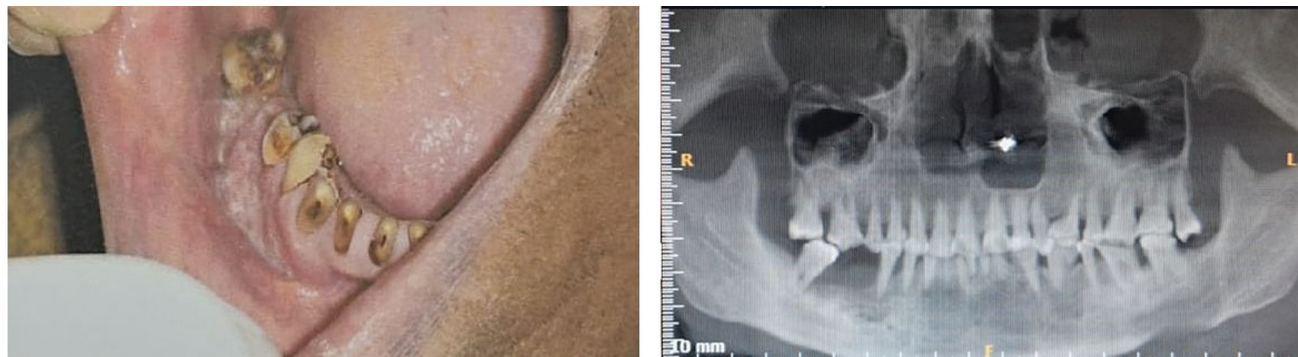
Clinical and radiographic image of a 54-year-old female patient with cancer of the lower right alveolus with no known risk factors apart from periodontitis.
